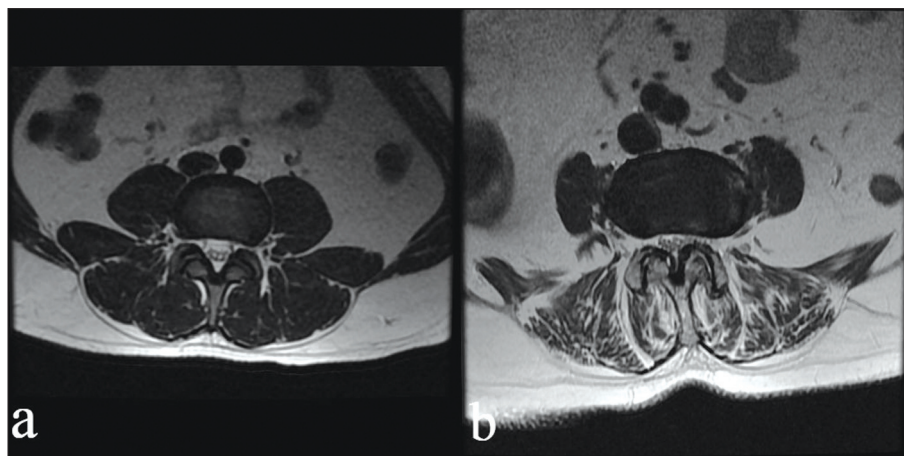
Axial T2-weighted MRIs with a negative NRSS (a) and a positive NRSS (b).
